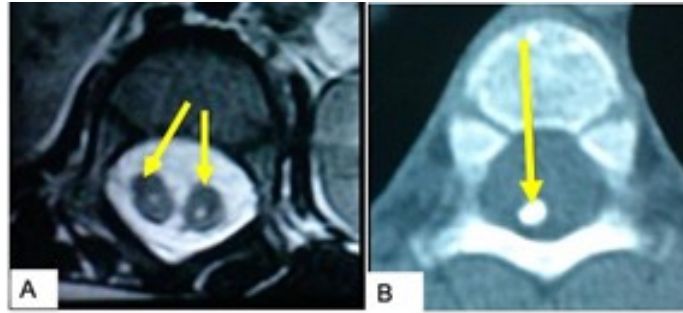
Split cord malformation (SCM). (A) MRI of the dorsal spine (axial view) diplomyelia and (B) CT scan of dorsal spine (axial view) showing bony septum. Source: Figure by authors.
